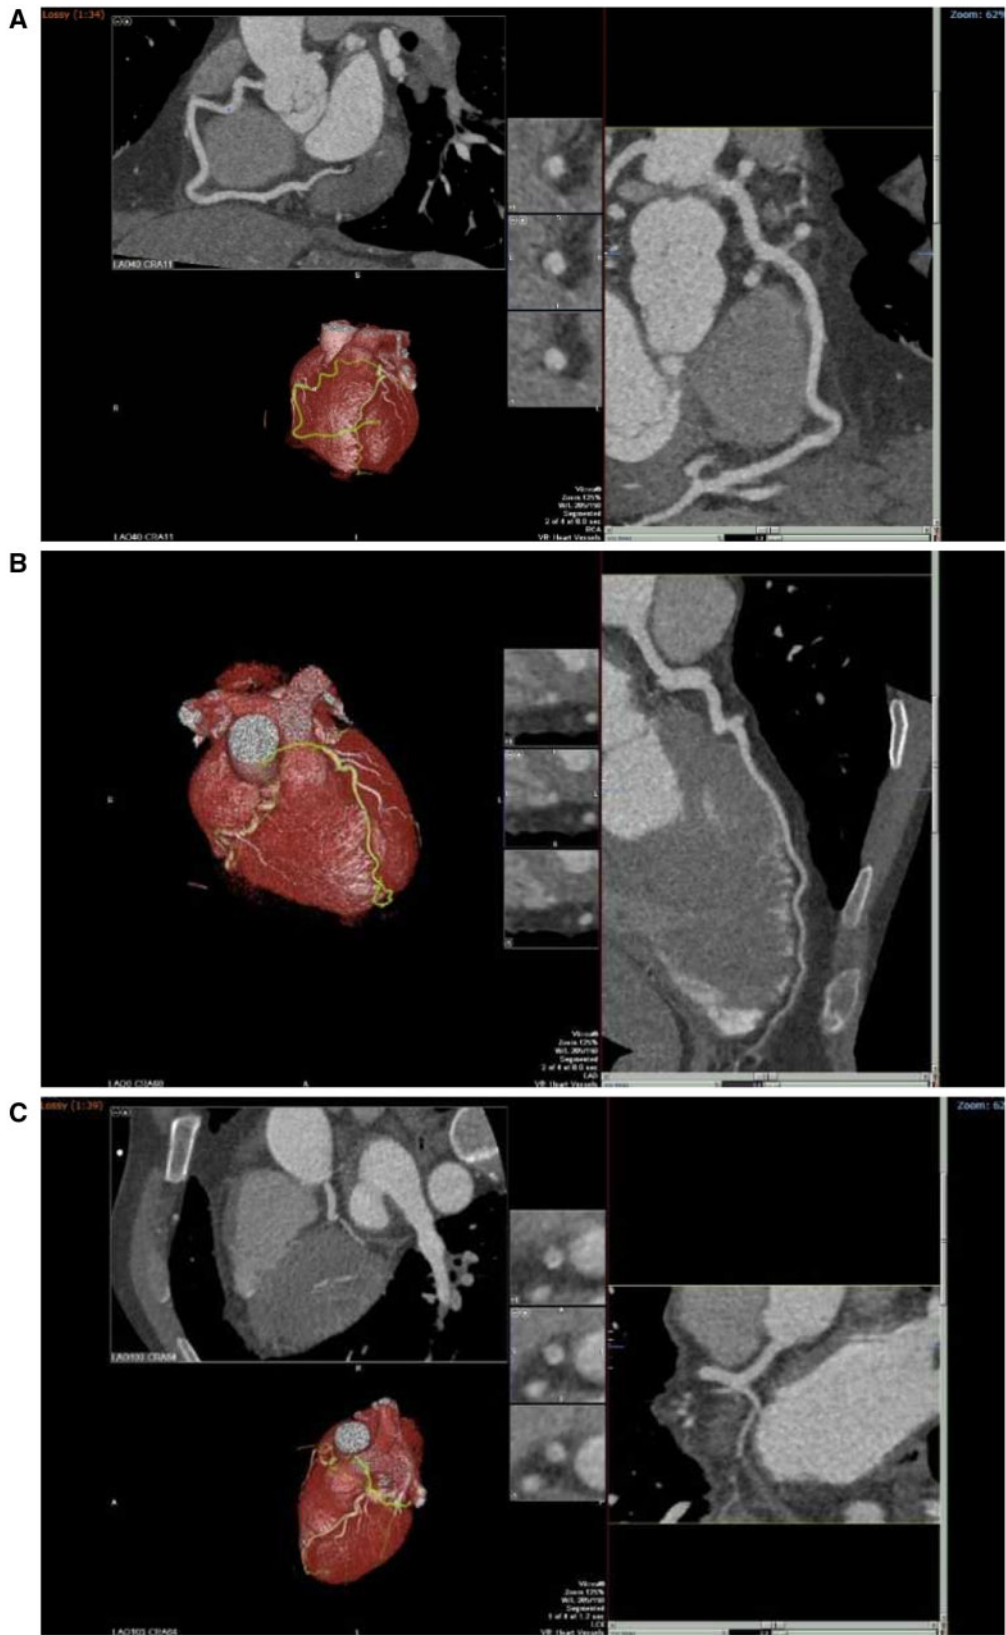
(A–C) Three-dimensional reconstruction using computed tomography coronary angiography showing normal coronary arteries.
